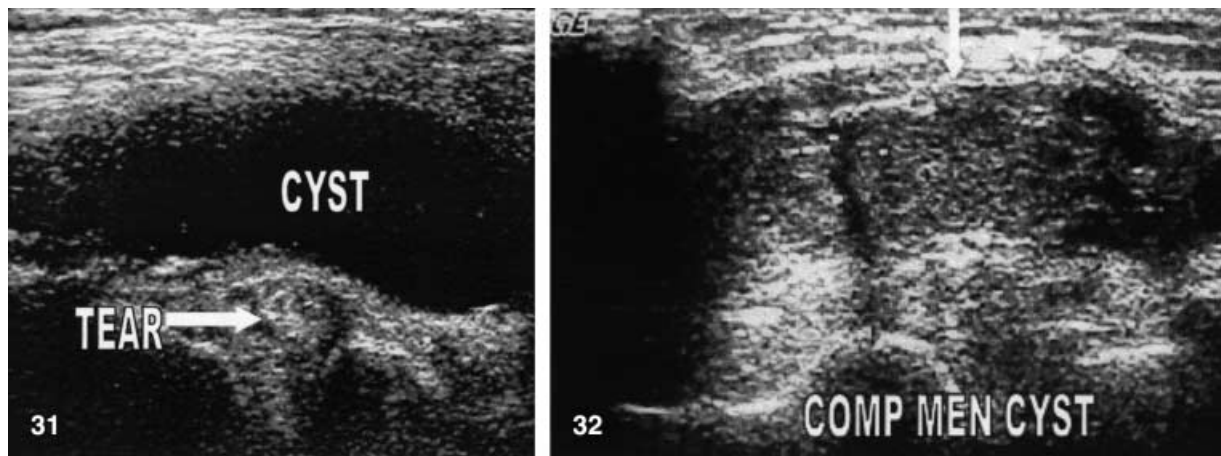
Meniscal cyst. Sagittal ultrasound image demonstrates a large meniscal cyst. An associated tear of the meniscus is also demonstrated (*arrow*)
